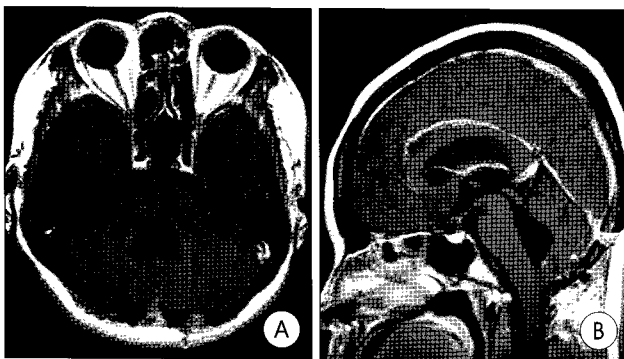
Postoperative follow-up Gd-enhanced T1-weighted axial (A), and sagittal images (B): after gross total removal of the epidermoid cyst, the fourth ventricle restored to normal contour. However, the previous dilated ventricular size does not come back to normal.
